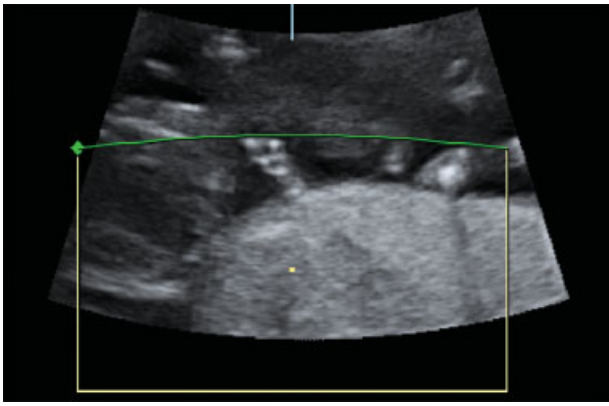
Two-dimensional ultrasound view (orthogonal plane) of suspected ectrodactyly on right hand at 13^{2/7} weeks of gestational age.
